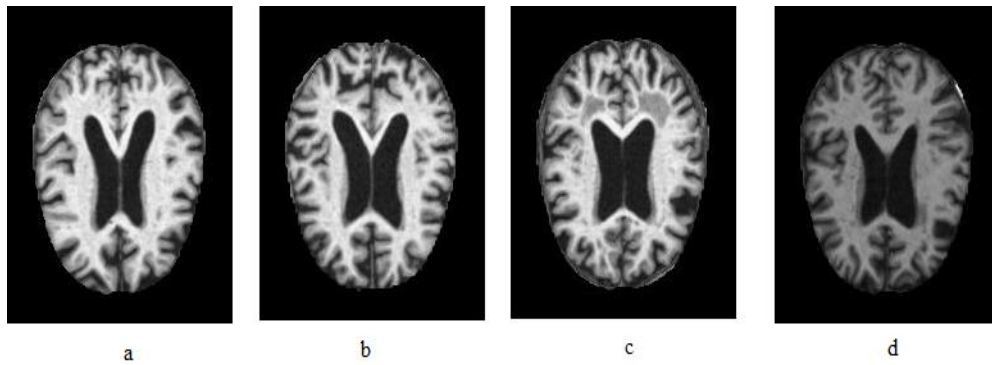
Different states of AD presented by MRI images (a) mild dementia; (b) moderate dementia; (c) nondemented; and (d) very mild dementia.
